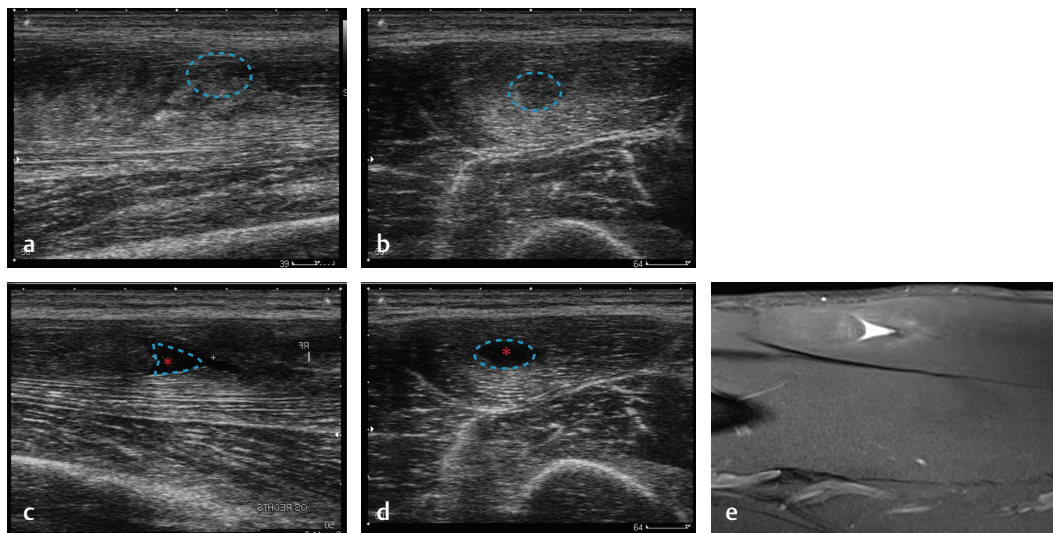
(a) Hematoma echo-rich area longitudinal scans. (b) Hematoma echo-rich area transversal scans. (c) Hematoma retraction of the muscle fascicle longitudinal scans. (d) Hematoma retraction of the muscle fascicle transversal scan. (e) Sagittal section of a T2-weighted fat saturated image corresponding to (c).
